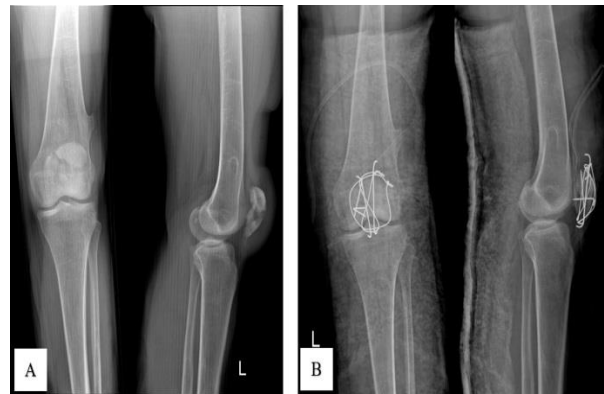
Radiographs of a comminuted patellar fracture, before (A) and after (B) fixation with pin and cerclage wire
